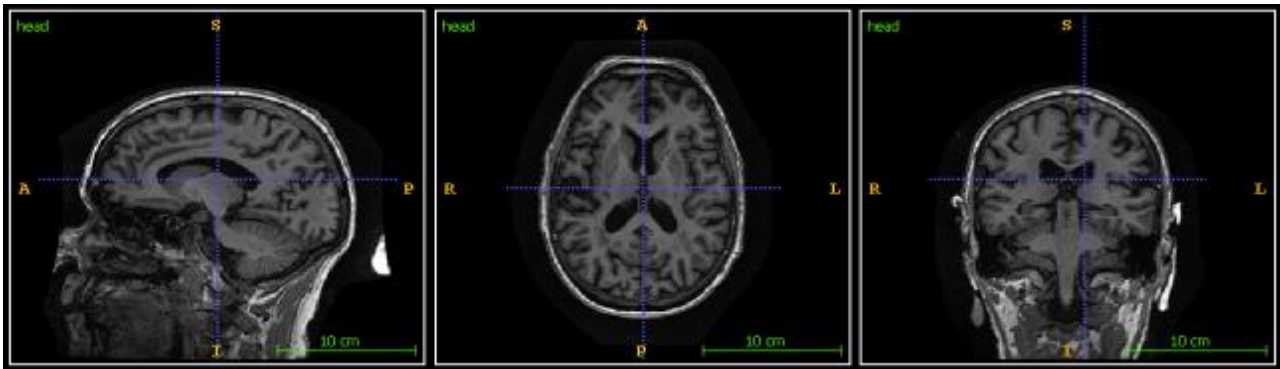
T1 weighted MRI from ADNI dataset. a) Sagittal view. b) Axial view. c) Coronal view.
